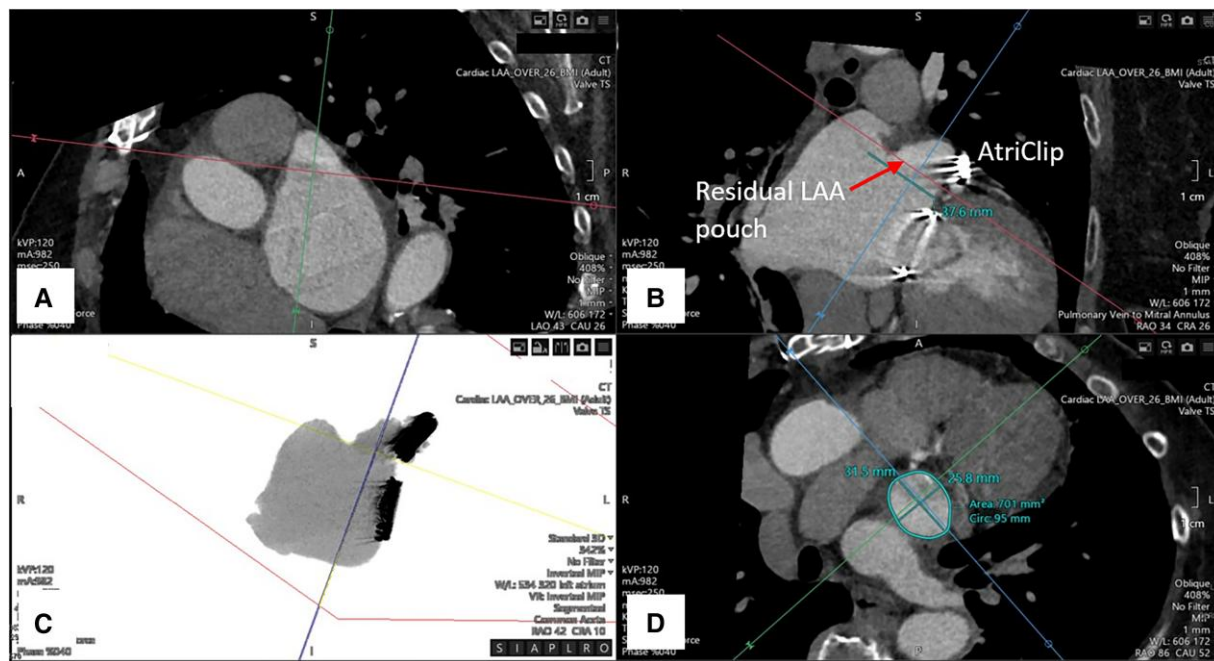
CT reconstruction of the LAA status post-surgical ligation (AtriClip), highlighting presence of the AtriClip with the residual pouch (B) the LAA ostium (A and C) with measurement of the residual communication (D).
